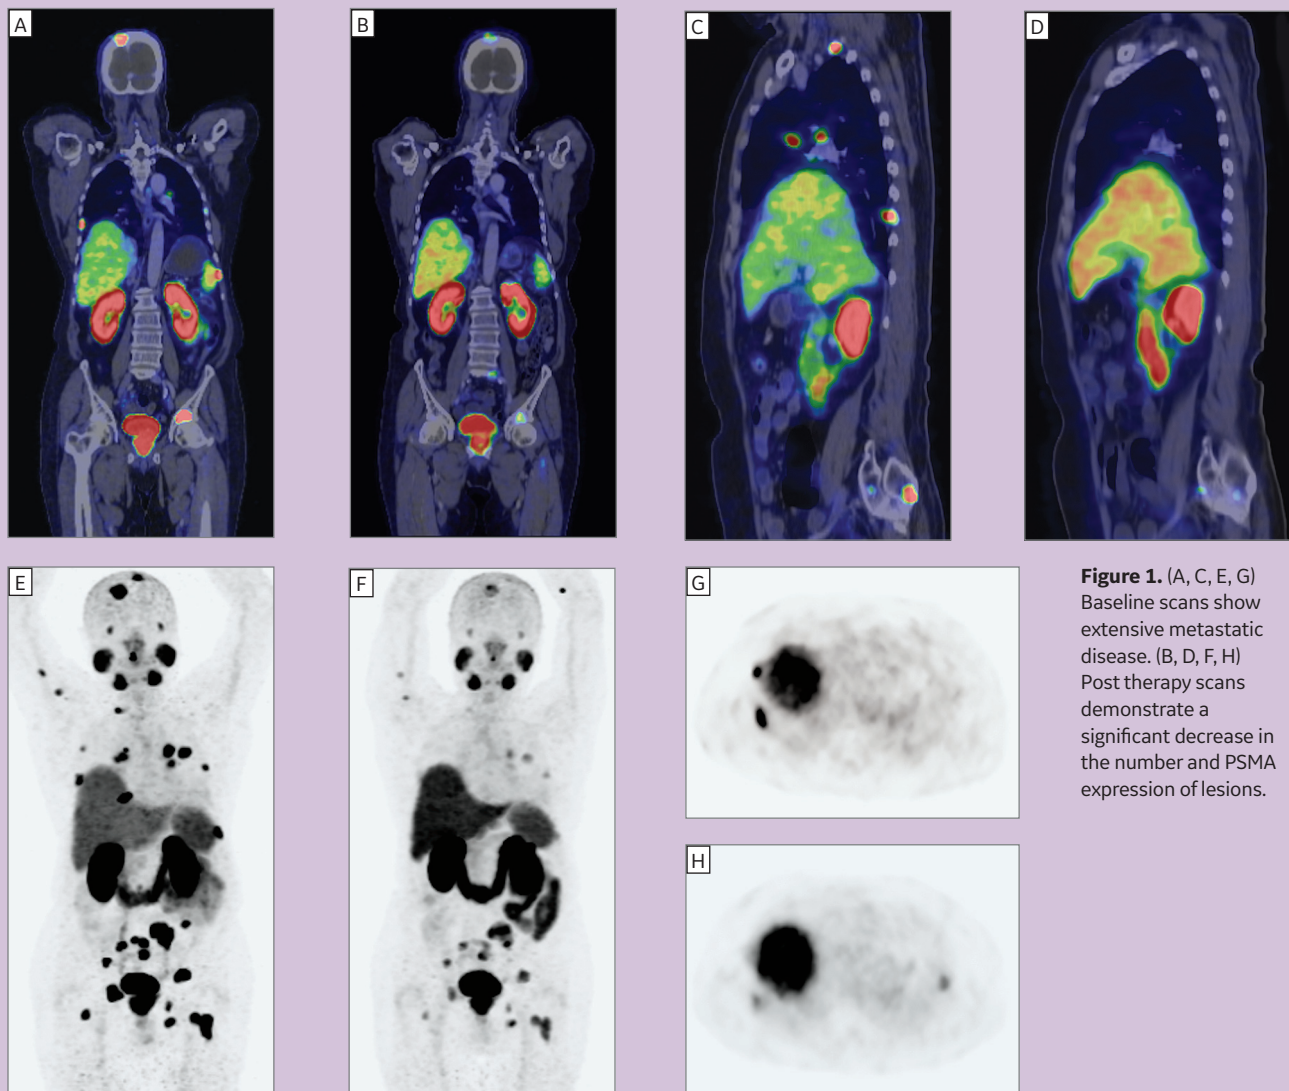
(A, C, E, G) Baseline scans show extensive metastatic disease. (B, D, F, H) Post therapy scans demonstrate a significant decrease in the number and PSMA expression of lesions.
